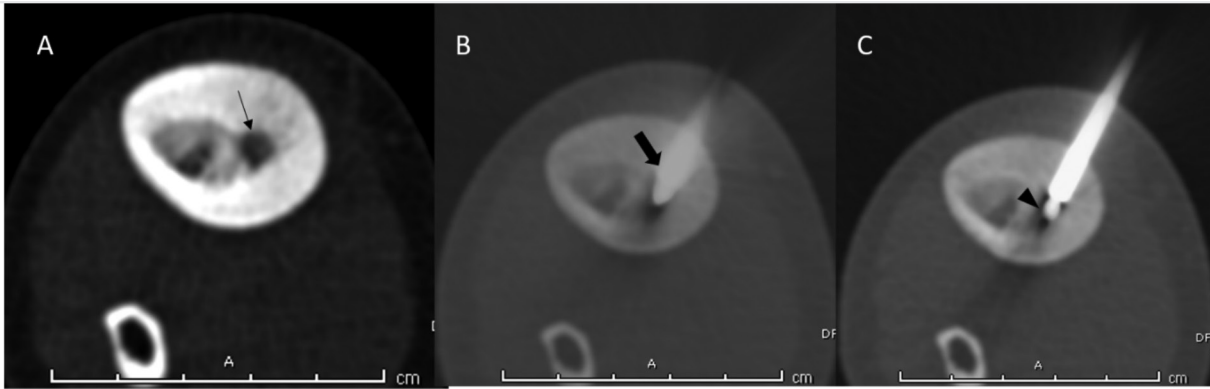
A-C. An 11-year-old male patient was admitted to the orthopedic clinic due to right leg pain that increased at night and continued for 6 months, and an OO lesion with a cortical nidus (black arrow) was found in the right tibial diaphyseal section. The patient underwent CT-guided radiofrequency ablation, and under sedoanalgesia, the 15-gauge coaxial system was placed in the nidus under local anesthesia (thick arrow). The RF probe with a 17 gauge 10 mm active tip was placed in the nidus through the coaxial system (arrowhead), and the lesion was ablated for 6 minutes at 90 C
